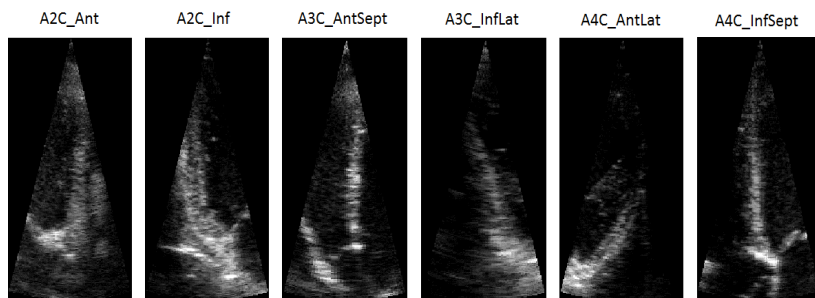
Six grayscale wall motion videos acquired from anterior and inferior apical 2-chamber, anteroseptal and inferolateral apical 3-chamber and anterolateral and inferoseptal apical 4-chamber views. The videos were presented to the cardiologist for decision making.
